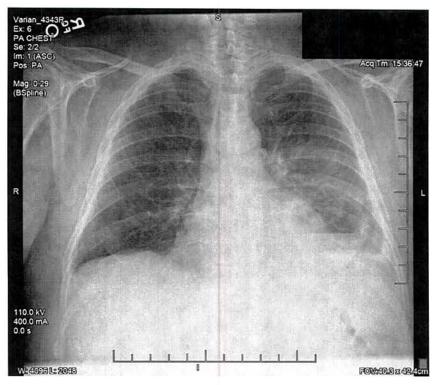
Chest radiograph showing the interval development of a left lower lobe consolidation with an air-fluid level and pleural effusion.
